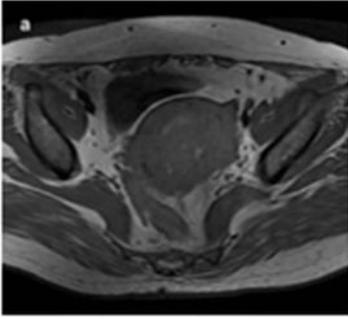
a: The Axial T1-weighted imaging
